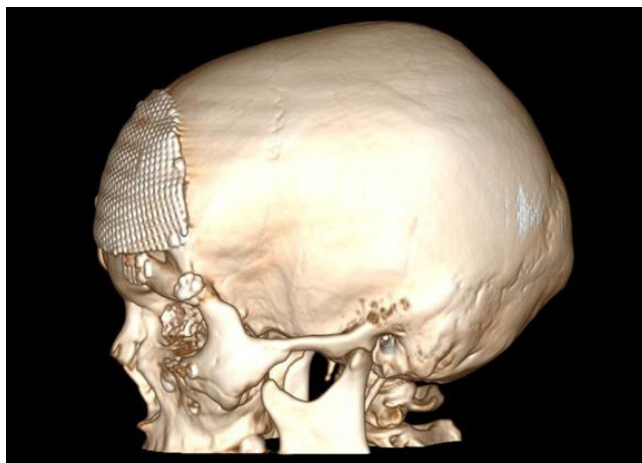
Computed tomography: 3D skull reconstruction (side view)
